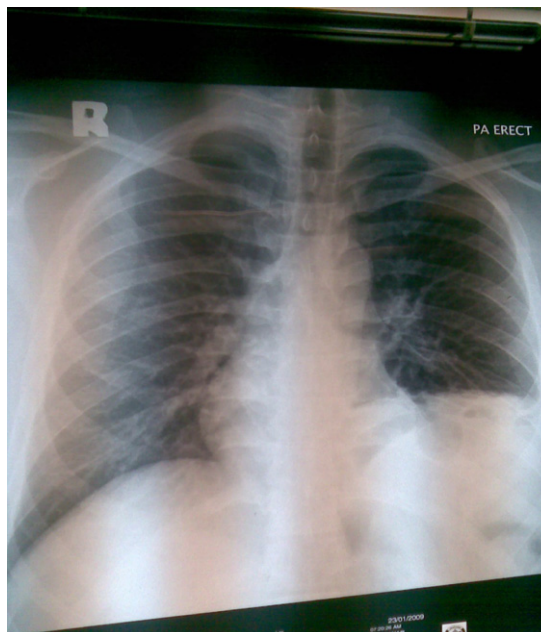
Chest x-ray (PA view) showing raised left hemidiaphragm and left lower zone opacity.
